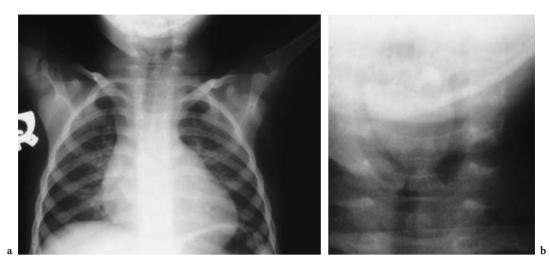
Radiolucent foreign body. AP (a) chest radiograph and magnified view (b) reveal an impacted piece of unchewed chicken in the cervical esophagus outlined by esophageal air
